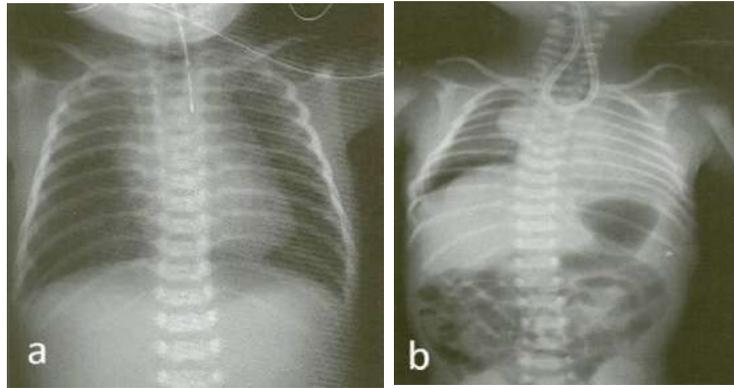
Thoracoabdominal radiograph, esophageal atresia:
